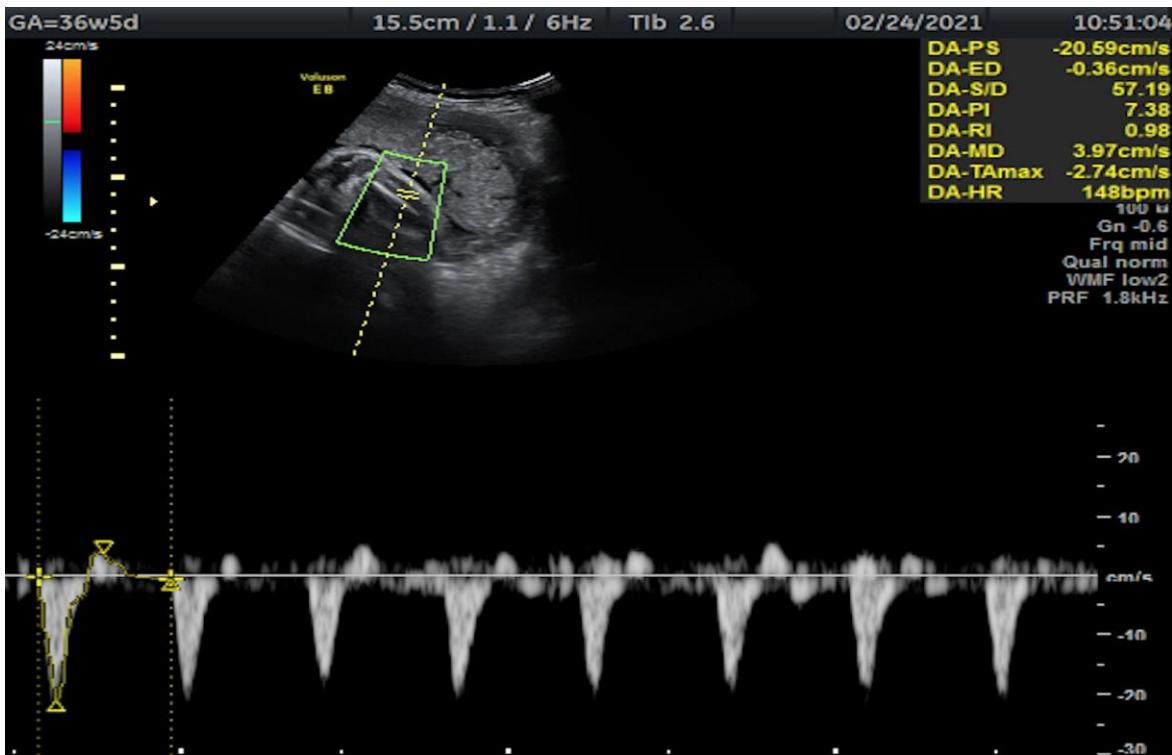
Doppler examination manual measurement technique for the fetal tibial artery at 36+5 weeks demonstrates the reverse flow of abnormal TA-PI (PI>95th percentile).
